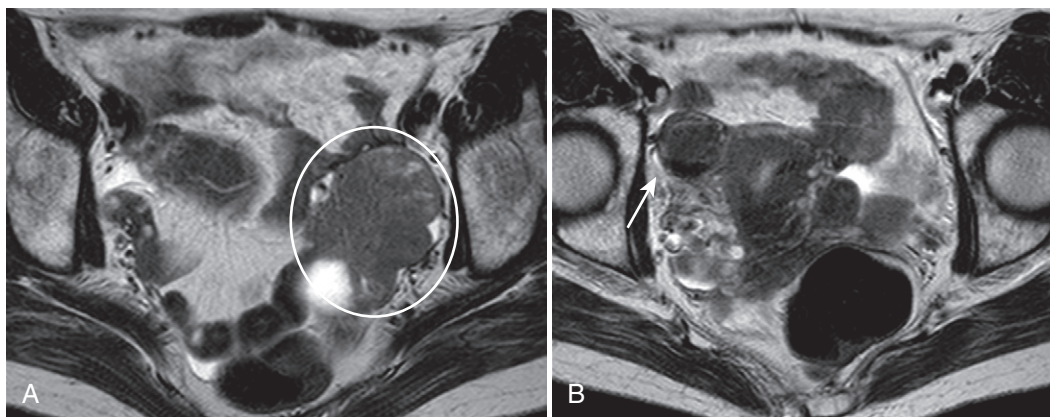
Metastatic ovarian lesions. A and B, Axial T2-weighted images. An amorphous solid mass replaces the left ovary (circle in A) and a smaller, more hypointense lesion mildly expands and distorts the right ovary (arrow in B).
